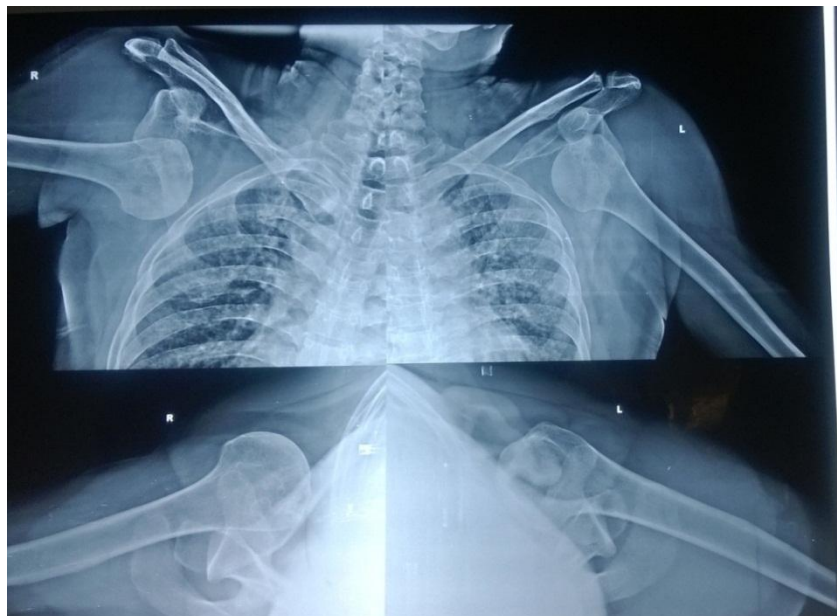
X-ray showing bilateral anterior shoulder dislocation
